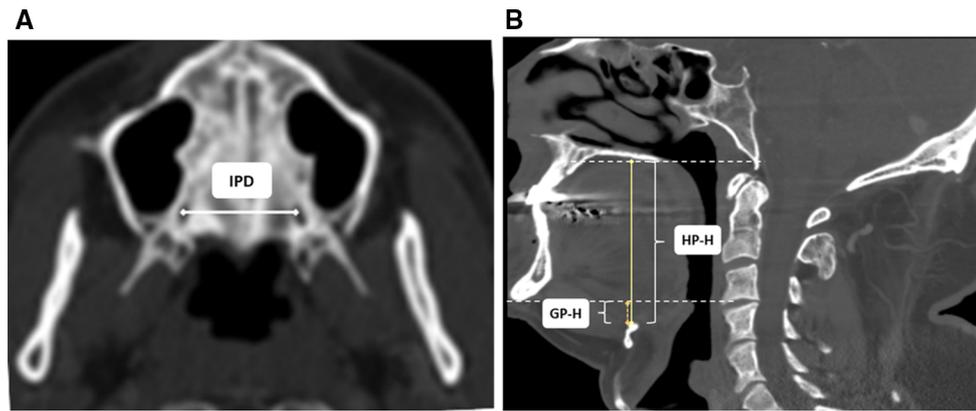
a Measured dimensional CT parameters on a hard palate axial computerized tomographic (CT) scan. b Midsagittal CT scan. *IPD* inter-ptyergoid distance, *HP-H* hard palate-to-hyoid distance, *GP-H* gnathion plane-to-hyoid distance
